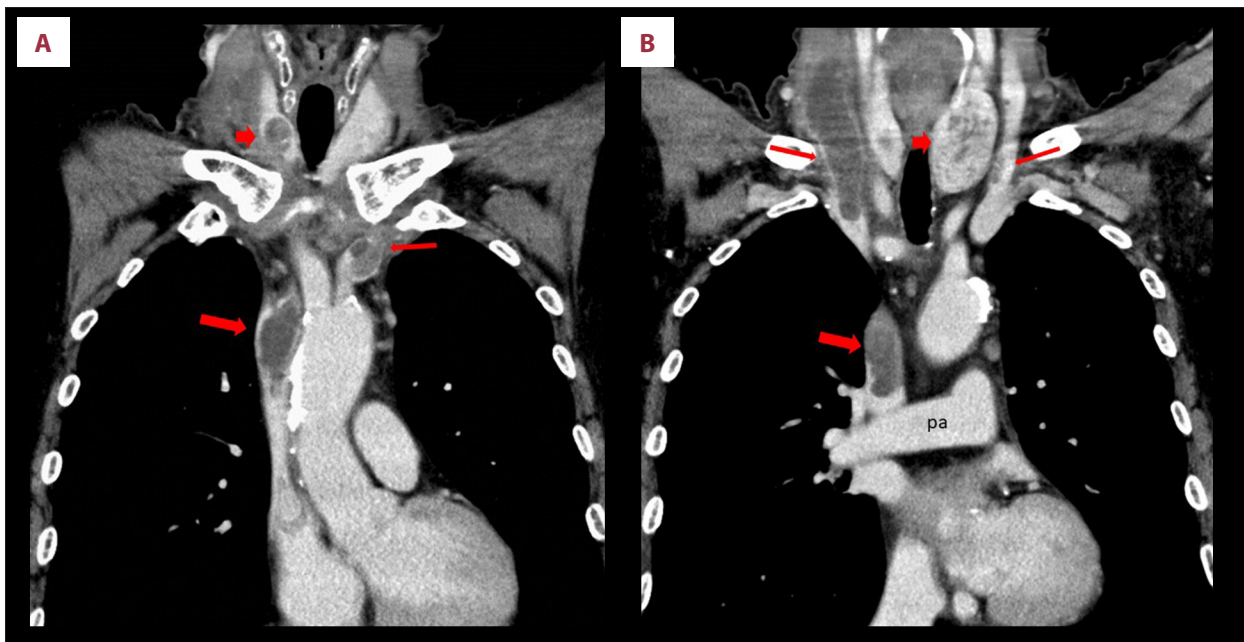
(A) Coronal section of contrast-enhanced CT of the thorax. There were filling defects in the superior vena cava (thick arrow) and left brachiocephalic veins (thin arrow). A focally calcified 2-cm tumor was seen in the right thyroid gland (arrow head). (B) Coronal section of contrast-enhanced CT of the thorax. The filling defects were observed in the superior vena cava (thick arrow) and in bilateral internal jugular veins (thin arrows). The pulmonary artery (pa) was free of disease. An encapsulated, 2×4 cm tumor was also seen in the left thyroid gland (arrow head).
